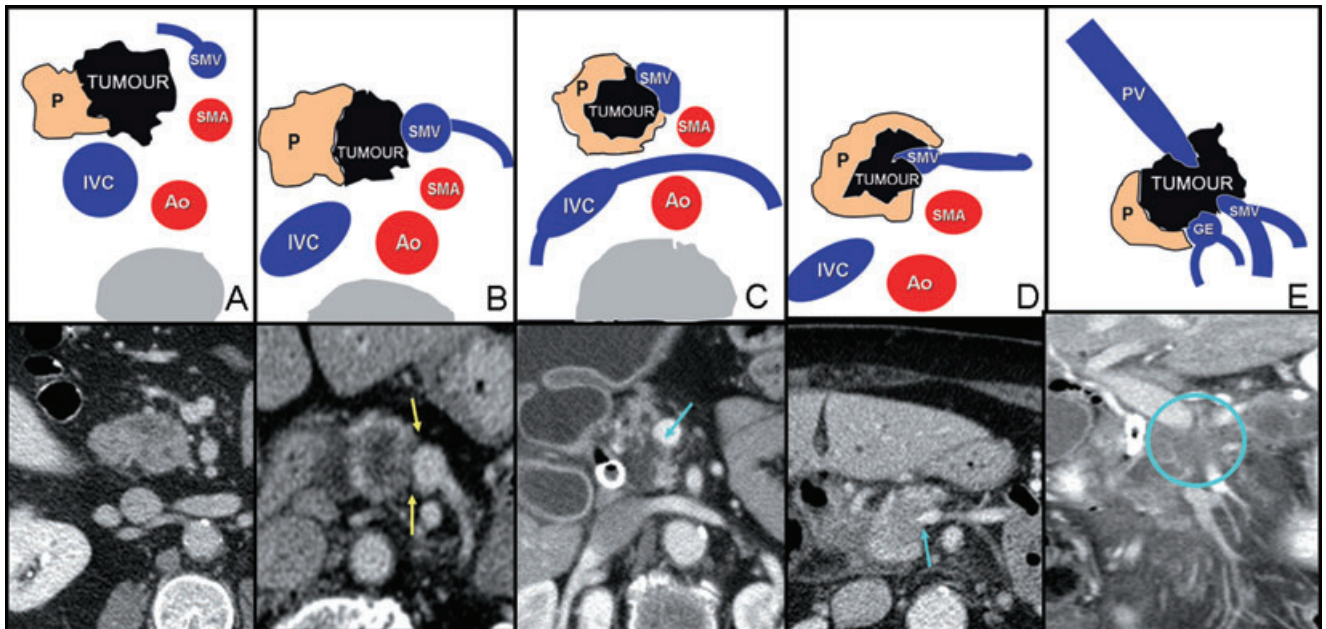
Raptopoulos computed tomography (CT) grading system for Pancreaticobiliary Neoplasms. (A) Grade 0: no vascular involvement with interposition of either pancreatic parenchyma or fat between the vessel and the tumour. (B) Grade 1: loss of the fat plane between the tumour and vessel *without* vessel distortion. (C) Grade 2: slight flattening or indentation of vessel, or surrounding up to 2/3 the vessel perimeter. (D) Grade 3: tumour extends around at least 2/3 of the vessel perimeter, changing its contour and narrowing the lumen; sometimes referred to as the ‘teardrop sign’. (E) Grade 4: occlusion or obliteration of vessel without option for reconstruction
